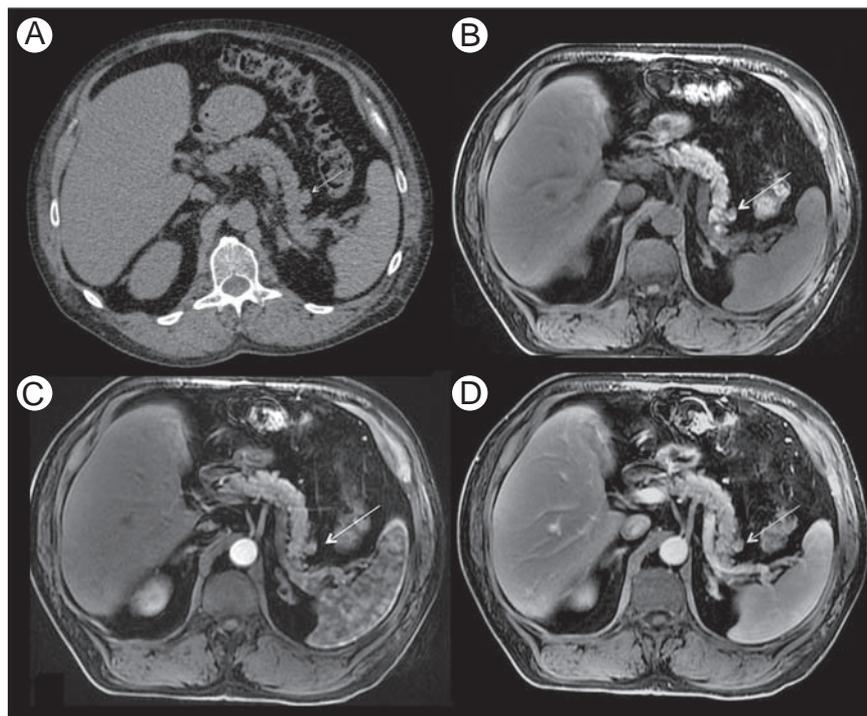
Prominent pancreatic lobulation mimicking metastasis in a 64-year-old woman with previous renal cell carcinoma. Unenhanced CT (A) shows a well-defined exophytic focal mass (arrow) that is isodense relative to the surrounding pancreas and isointense on axial fat-suppressed unenhanced (B), postcontrast arterial (C), and portal (D) T1-W phases (arrows). These findings are consistent with pancreatic lobulation.
